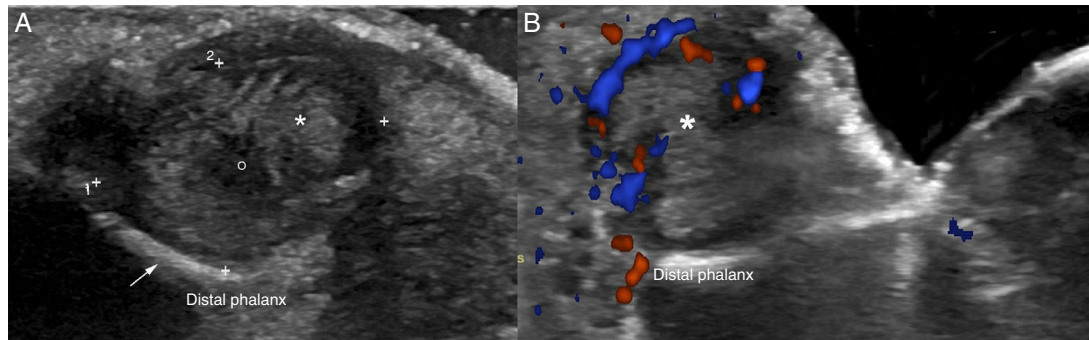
Nail ultrasound in keratoacanthoma. A, Gray scale (longitudinal axis, right thumb, ulnar border) shows a hypoechoic tumor (asterisk, between + signs) with lower echogenicity centrally (o). Observe remodeling of the underlying bone surface (arrow). B, Color Doppler of the nail (longitudinal axis, right thumb, ulnar border) showing hypervascularity (in color) at the periphery of the tumor (asterisk).
